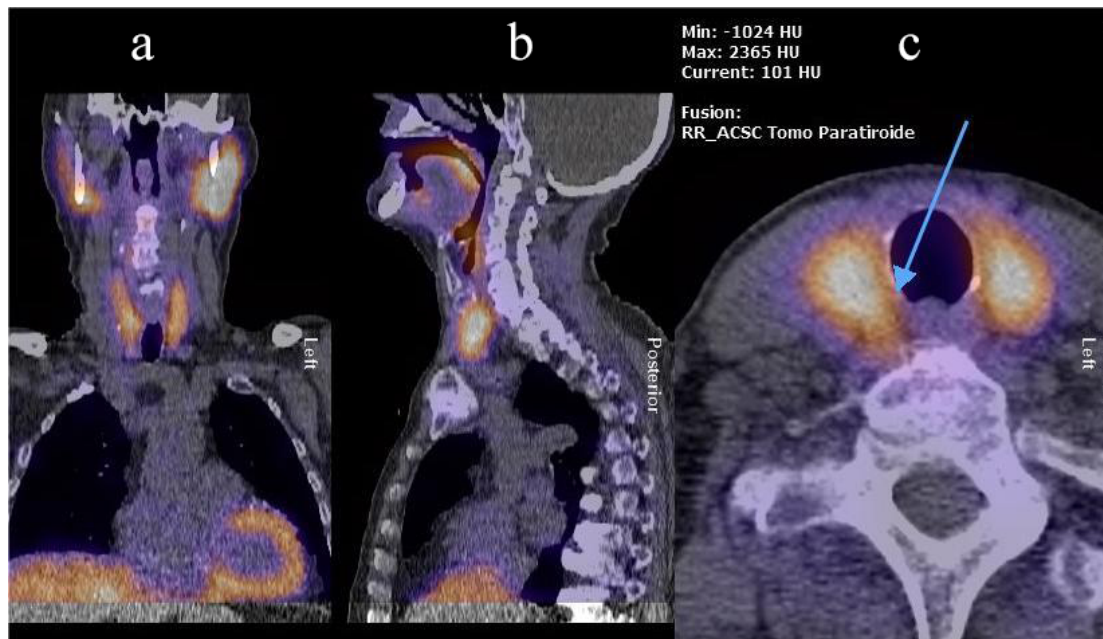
Case 4: SPECT/CT images with low-dose CT show suspected area corresponding to a nodulation located posteriorly to the middle third of the right thyroid lobe (the blue arrow indicates the location of the suspicious nodular area). (a) Coronal view. (b) Sagittal view. (c) Axial view. SPECT, single photon emission computed tomography; CT, computed tomography.
